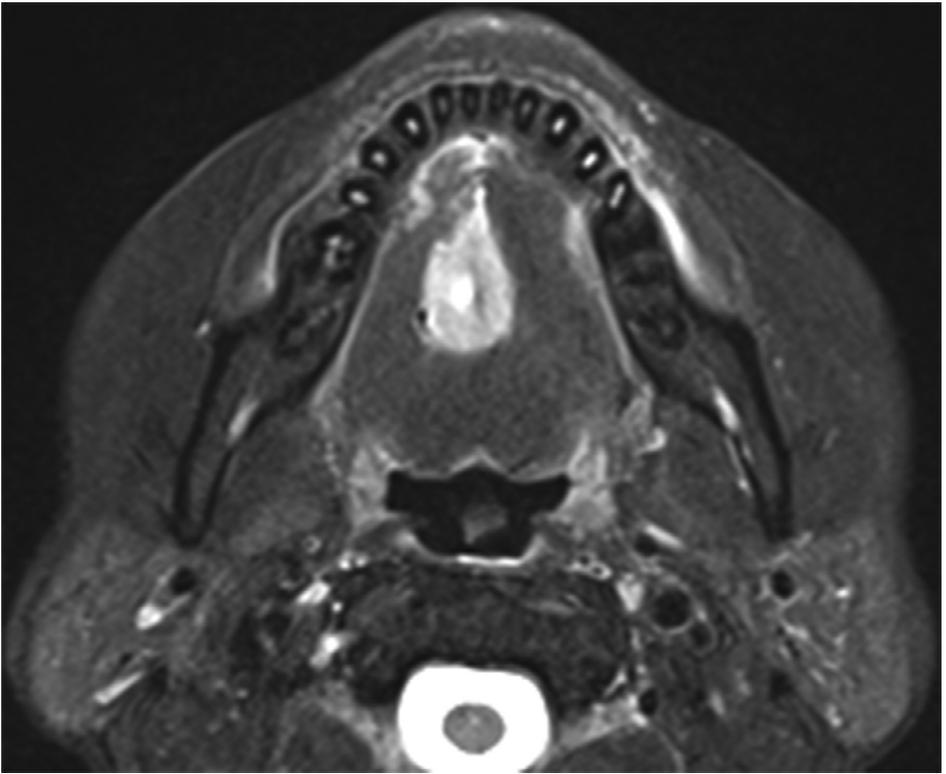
MRI axial view on T2-weighted image.
